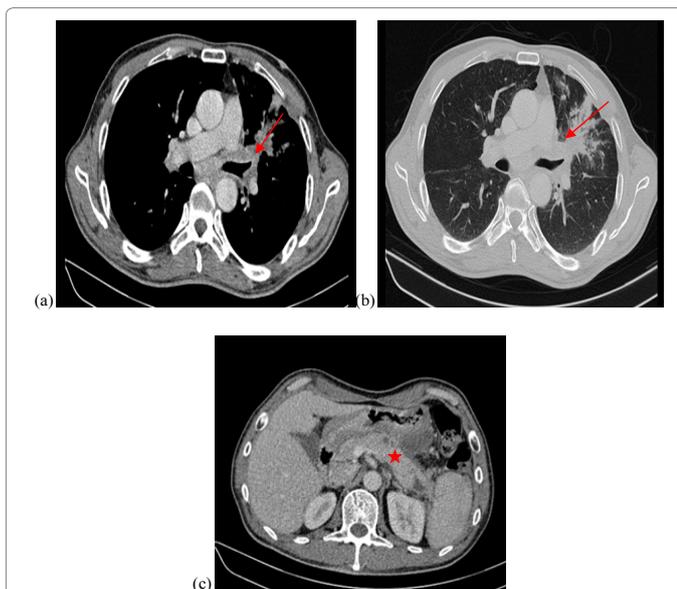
Enhanced CT scan of chest and abdomen showing notable regression in both pulmonary and pancreatic lesions after four cycles of chemotherapy.
